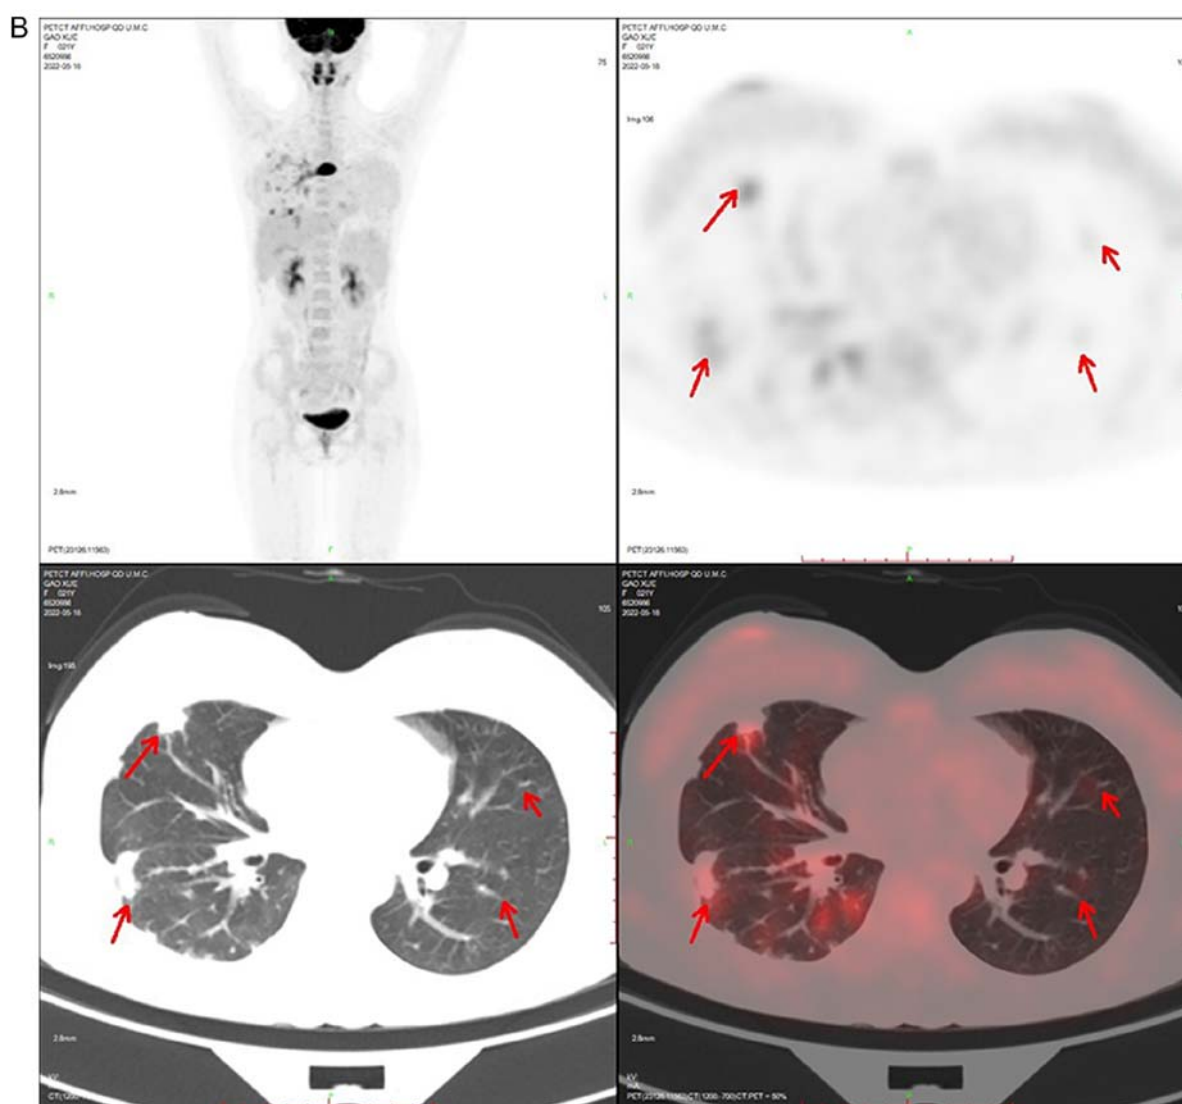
FDG-PET/CT images of a 21-year-old woman with choriocarcinoma presenting as a pulmonary embolism. (A) FDG-PET/CT images shows the region of hypermetabolic focus in the right pulmonary artery ($SUV_{max}=27.5$; indicated with an arrow). (B) FDG-PET/CT images shows low accumulation of FDG in the nodules ($SUV_{max}=7.2$; indicated with an arrow). SUV_{max} , maximum standardized uptake value; FDG-PET/CT, positron emission tomography with 2-(fluorine-18)-fluoro-2-deoxy-D-glucose/computed tomography.
